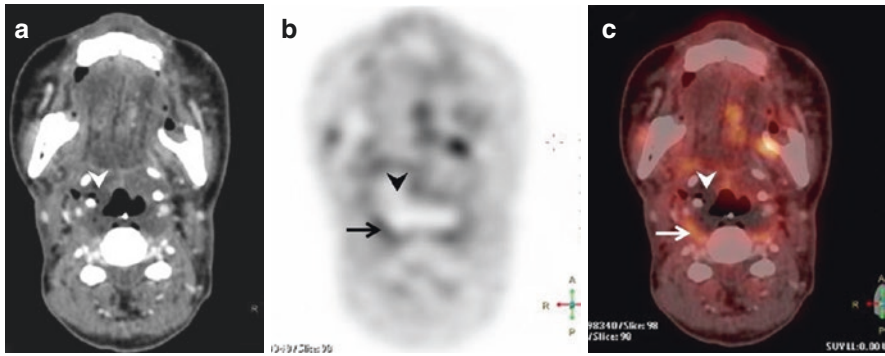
Mandibular Osteoradionecrosis. CT shows lytic defect in the left hemimandible with air pockets (*arrowhead* in a) due to ORN. Axial PET and fused PET/CT show peripheral rim of uptake in the surrounding inflamed tissues (*arrows* in b and c) with photopenia in the central necrotic portion. (d–f) Another variant of mandibular ORN, with diffuse sclerosis seen on CT (*arrowhead* in d) and intense uptake seen on PET (*arrows* in e and f)
